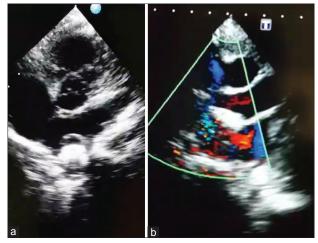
(a) Transthoracic echocardiography parasternal short-axis view after deployment of device across the communication. (b) Transthoracic echocardiography Doppler showing no residual shunt across the device
